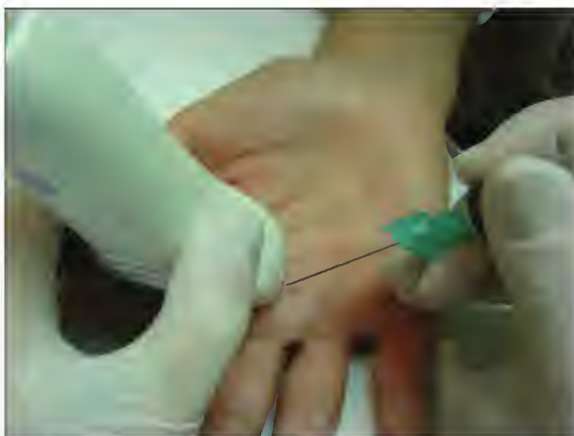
e69.7 Ultrasound-guided direct injection for flexor tenosynovitis of the hand.
